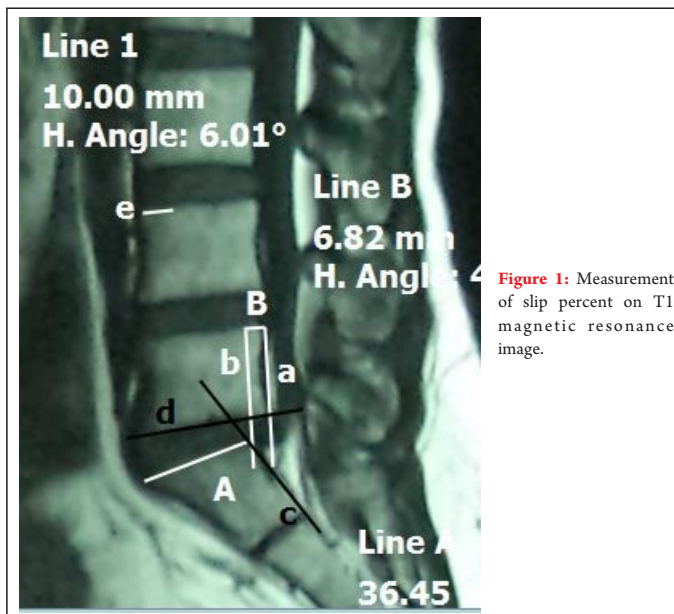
Measurement of slip percent on T1 magnetic resonance image.
